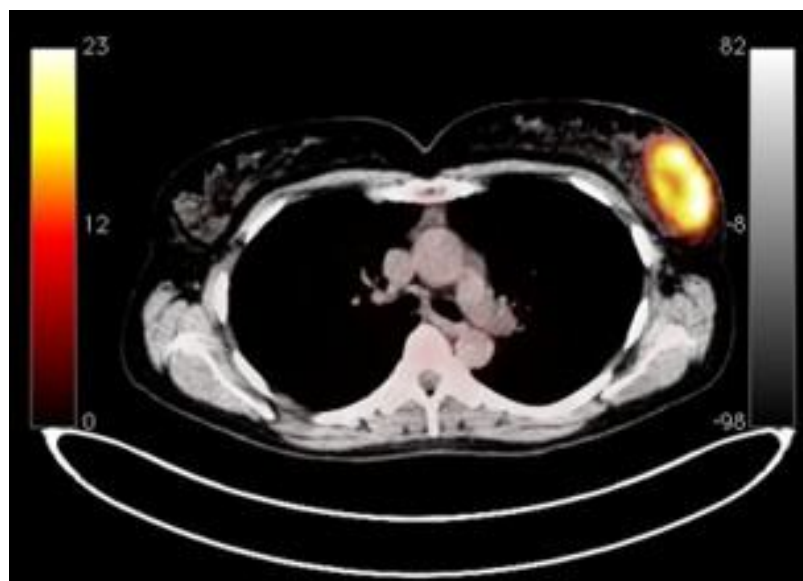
a) Whole-body PET/CT of case 1
